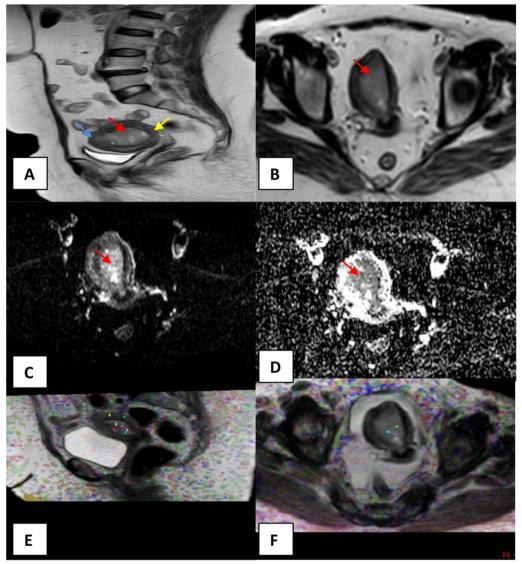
A 50-year-old postmenopausal female presented by abnormal vaginal bleeding. A, B *Sagittal and axial T2 WIs* irregular endometrial soft-tissue mass with ill-defined margins displaying intermediate SI (blue arrow). The mass distends and fills the endometrial cavity with myometrial thinning (red arrow). No cervical extension (yellow arrow). C *Axial DWI with b value of 1000 s/mm*² high SI of the endometrial soft-tissue mass denoting restricted diffusion (red arrow). D *Axial DW-ADC map image* shows low signal intensity of the endometrial soft-tissue mass (red arrow). Mean DW-ADC value of the mass = $0.784 \times 10^{-3} \text{mm}^2/\text{s}$. Mean DW-ADC values at areas of intact and infiltrated myometrium = 1.247 and $0.805 \times 10^{-3} \text{mm}^2/\text{s}$, respectively. E, F *Sagittal and axial DTI map images* values of DT-FA and DT-ADC (MD) in multiple ROI. Mean DT-FA and DT-MD values of the endometrial mass = 0.181 and $0.508 \times 10^{-3} \text{mm}^2/\text{s}$, respectively. Mean DT-FA and DT-ADC (MD) values at areas of infiltrated myometrium = 0.193 and $0.597 \times 10^{-3} \text{mm}^2/\text{s}$, respectively. Mean DT-FA and DT-ADC (MD) values at areas of intact myometrium = 0.517 and $0.367 \times 10^{-3} \text{mm}^2/\text{s}$, respectively. Diagnosis Pathologically proved endometrial papillary serous carcinoma
